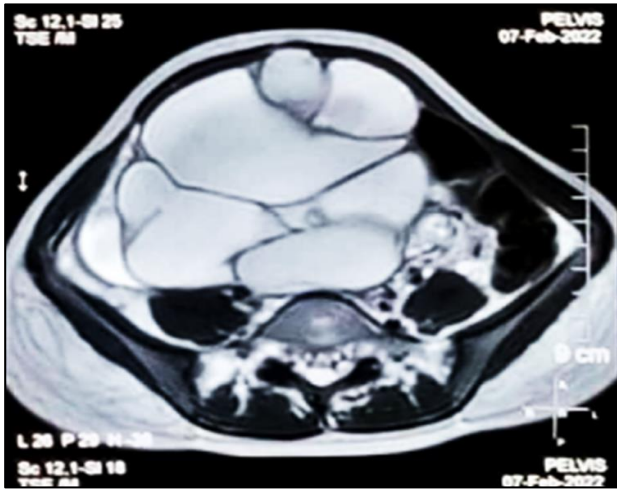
MRI image of the adnexal mass.
